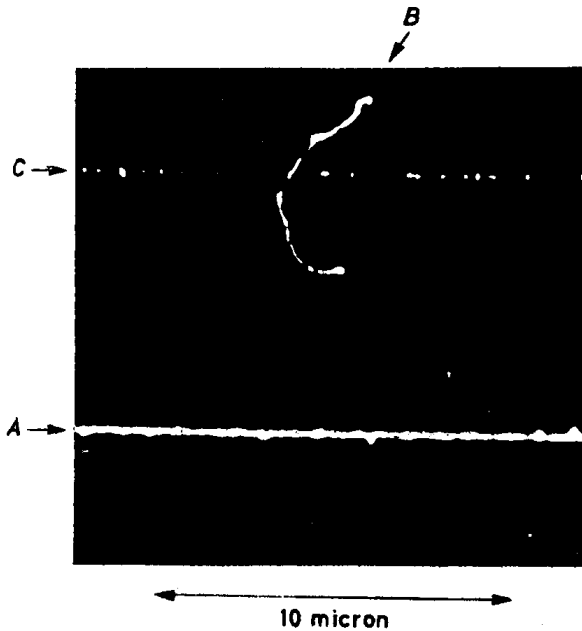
A, proton projected by a neutron; B, slow electron (20 kV) X-ray; C, fast electron (200 kV) γ -ray
